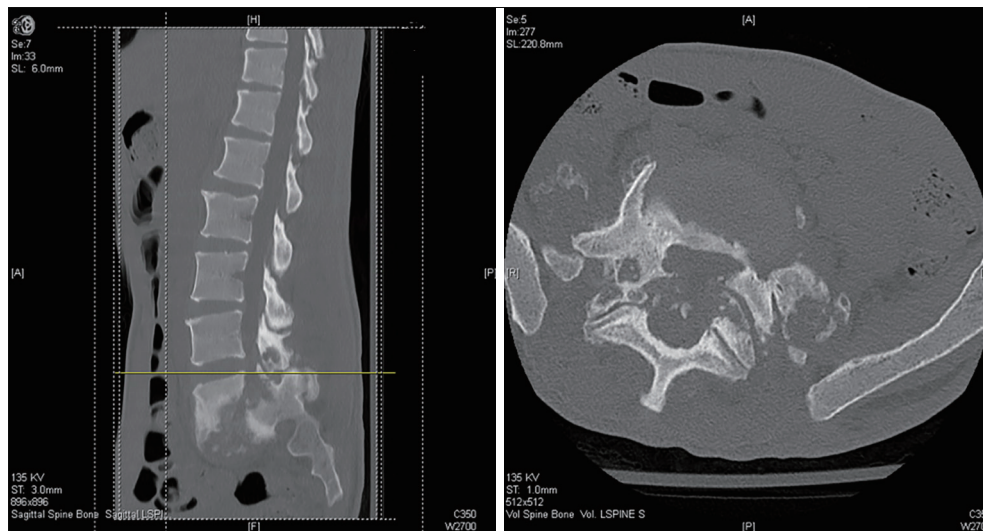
CT of lumbar spine (L4-5) on presentation. CT, computerized tomography.
